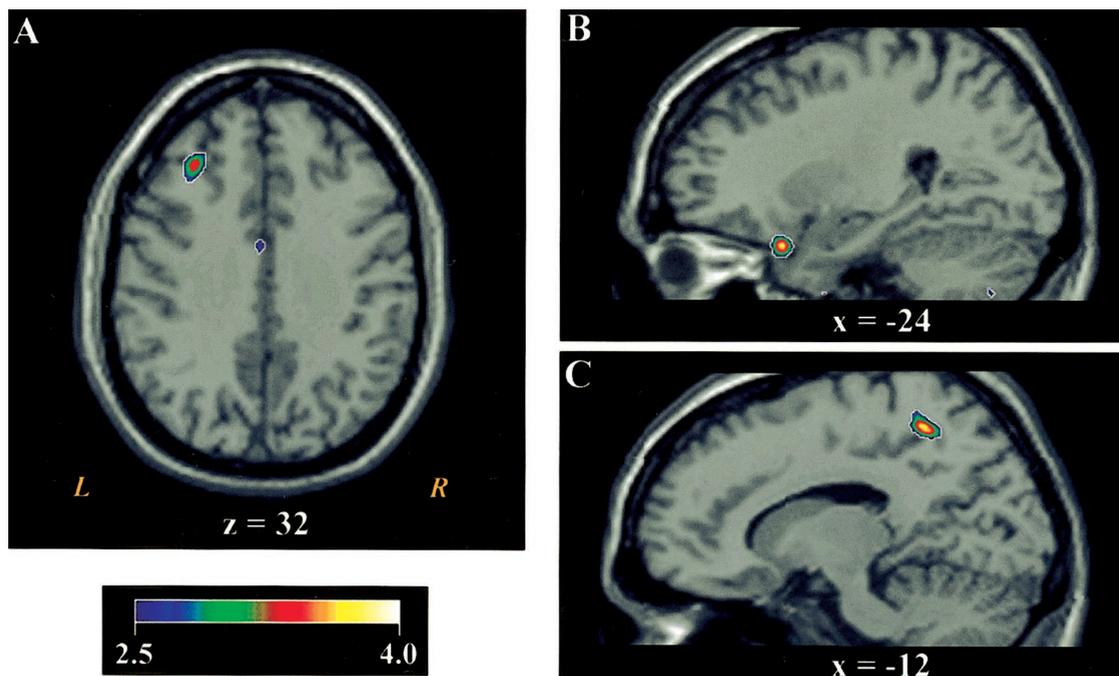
Areas of increased regional cerebral blood flow during delayed spatial alternation relative to the sensorimotor control. A: Transverse slice displaying the middle frontal gyrus focus at  $z = 32$ . B: Sagittal slice displaying the posterior orbital focus at  $x = -24$ . C: Sagittal slice displaying the precuneus focus at  $x = -12$ . All figures were produced by resampling the positron emission tomography Z-score image to a  $1\text{-mm}^3$  pixel resolution and templating the data to display only Z scores greater than 2.5 and by overlaying the resulting data on a high-resolution Talairach warped anatomical magnetic resonance image. Z scores are color coded according to the color bar at the bottom left side of the figure. L = left; R = right.
